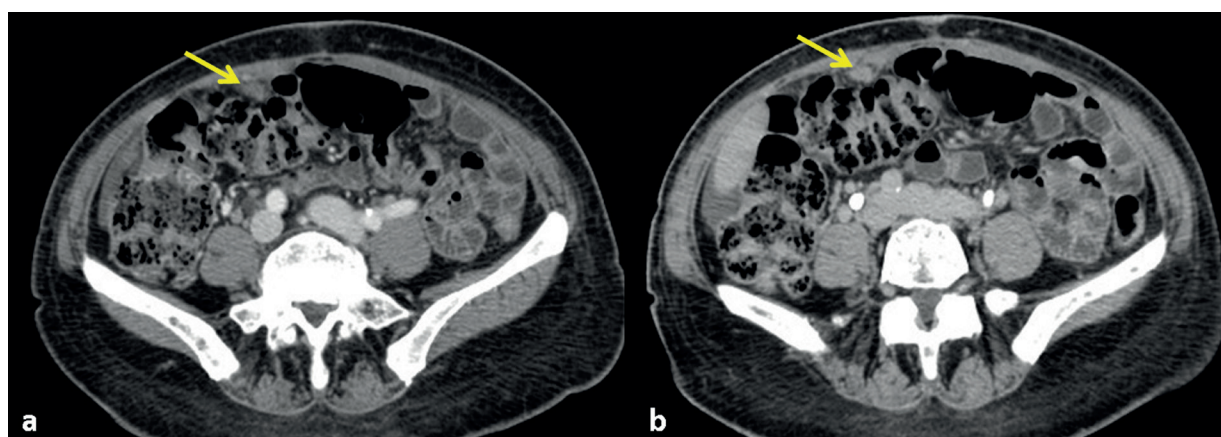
a-b. Axial CT images obtained in portal (a) and delayed (b) phases. Experienced readers assigned a score of 5 (certainly present) in all reading sessions (arrow in a and b), as confirmed by SOR (nodular pattern of carcinomatosis involving the omentum) = True positive case.
